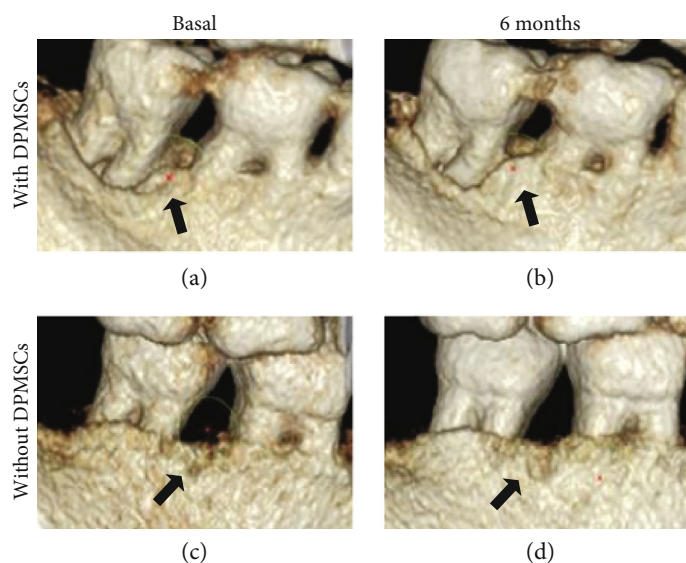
Cone beam volumetric tomography and radiography in which the growth of bone tissue is observed in the EG with DPMSCs (a, b) and the CG without DPMSCs (c, d).
